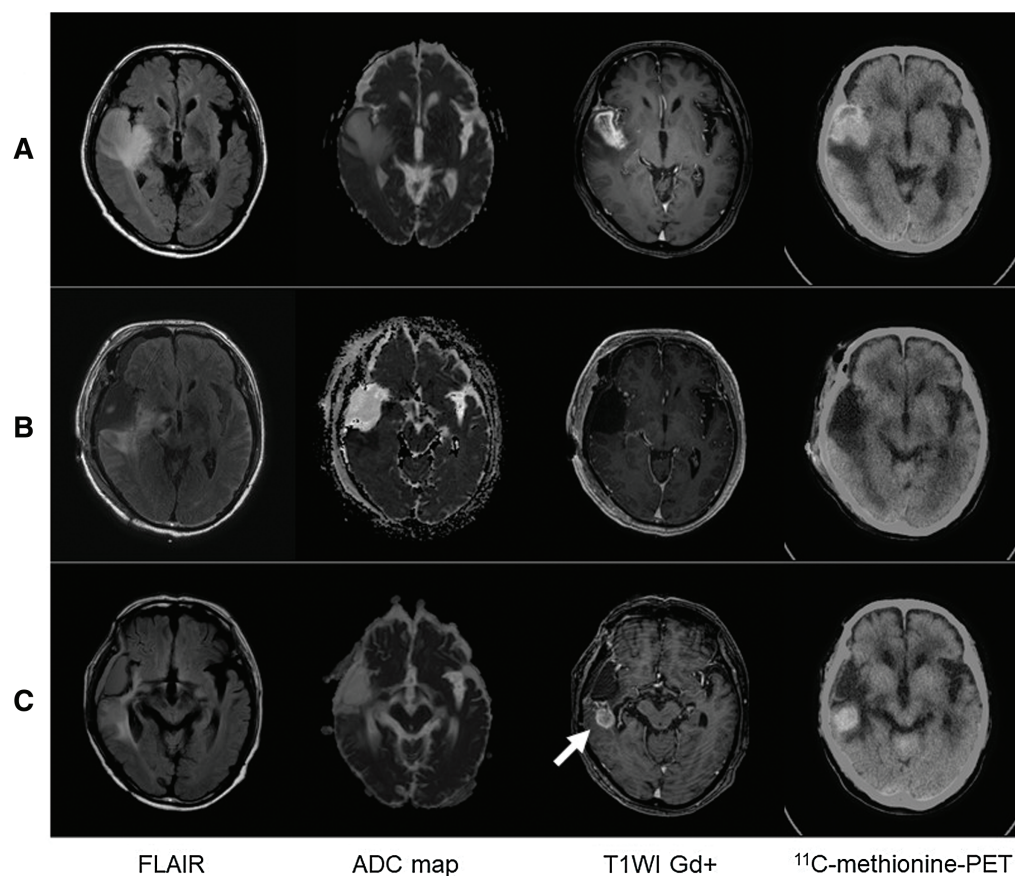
Representative MRI scans and MET-PET of the patients treated at our institute. The scans were obtained before and after surgery and at the first recurrence. (A) Contrast-enhanced T1-weighted MRI revealed left temporal tumor with surrounding FLAIR high-signal lesion. (B) The enhanced tumor was totally removed. (C) New enhanced lesion appeared around resection cavity (arrow). The new recurrent tumor showed high uptake in ¹¹C-methionine PET. MRI: magnetic resonance imaging.
